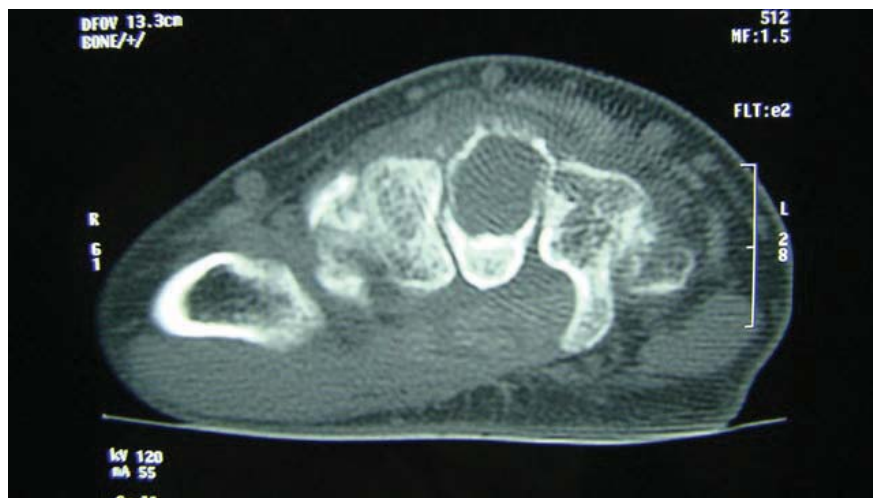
CT scan showing involvement of the capitate bone.
